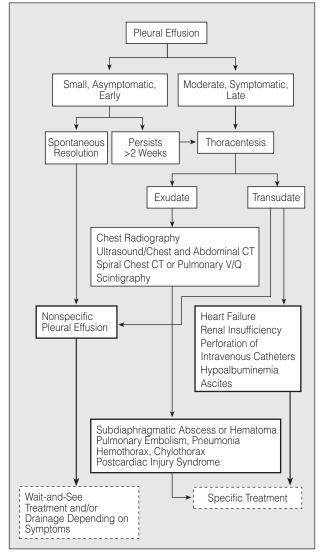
Algorithm for the management of pleural effusion after cardiac or abdominal surgery. CT indicates computed tomography; and V/Q, ventilation/perfusion.
